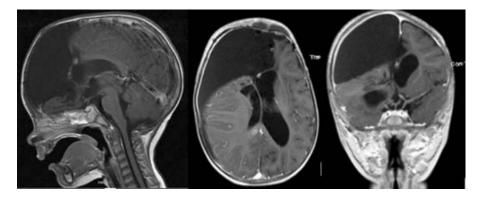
Postoperative MRI with gadolinium: gross total removal of the lesion with residual right subdural collection.
